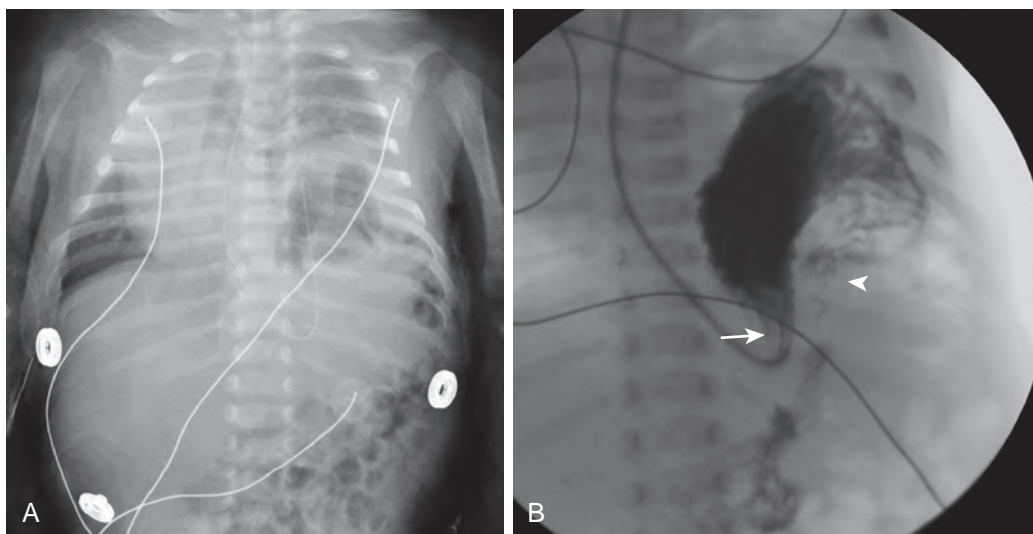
Gastric volvulus. A. Abdominal radiograph shows congenital left diaphragmatic hernia. B. Upper gastrointestinal examination shows gastric volvulus associated with the herniated stomach. Arrow identifies the gastroesophageal junction. There are both organoaxial, with greater curvature superior to lesser curvature, and mesenteroaxial, with duodenum (arrowhead) to the left of the stomach, components to the volvulus.
